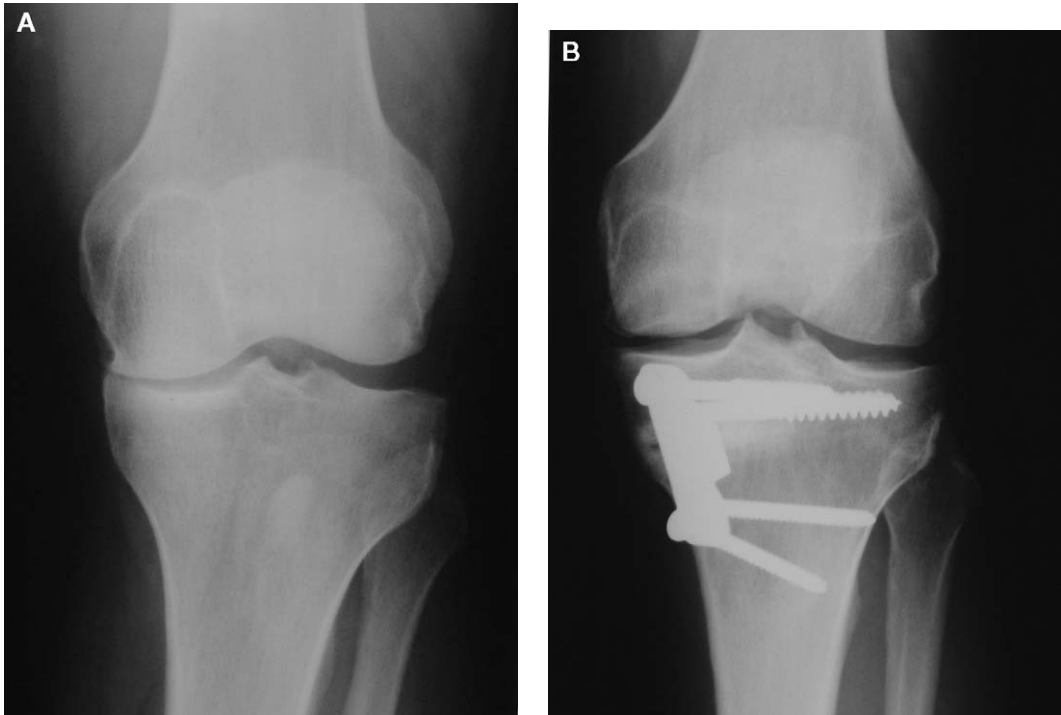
(A) Preoperative and (B) postoperative anteroposterior (AP) radiographs of a patient with a varus deformity and MCL insufficiency. This patient underwent a medial opening wedge osteotomy to correct the malalignment.
